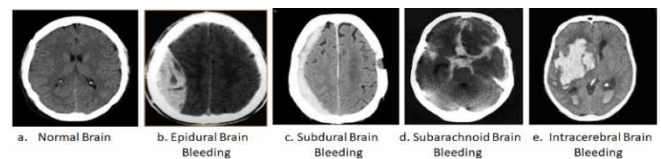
Normal Brain CT Scan Results and Bleeding
